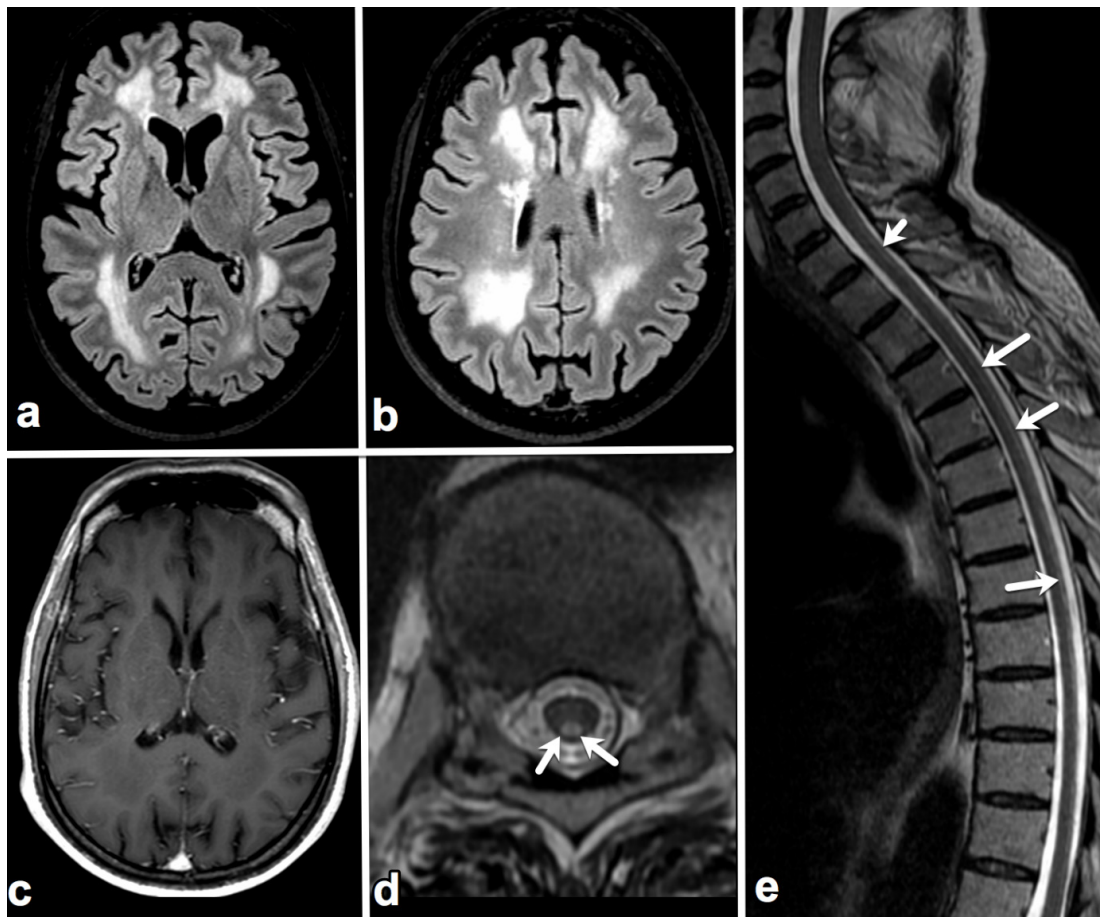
MRI Brain: Axial FLAIR images show bilateral fairly symmetrical hyperintensities in deep and periventricular white matter of frontal, parietal and posterior temporal regions (a, b). Axial post-gadolinium contrast enhanced T1-weighted image show no enhancement in corresponding hypointense areas (c). Axial (d) and sagittal (e) T2-WI of spine show symmetrical posterior column hyperintensities, giving the appearance of “inverted v sign” (arrows) on axial images (d).
